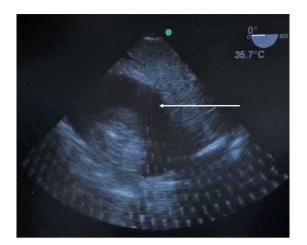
Transesophageal echocardiography image of the cardiac chamber The transgastric apical short-axis view of pericardial effusion (arrow).
